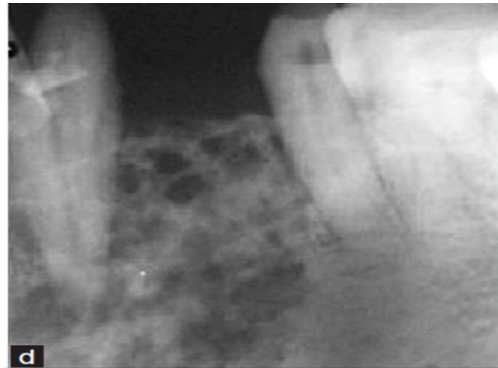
intraoral periodical radiograph showing honeycomb type (More et al, 2012).
